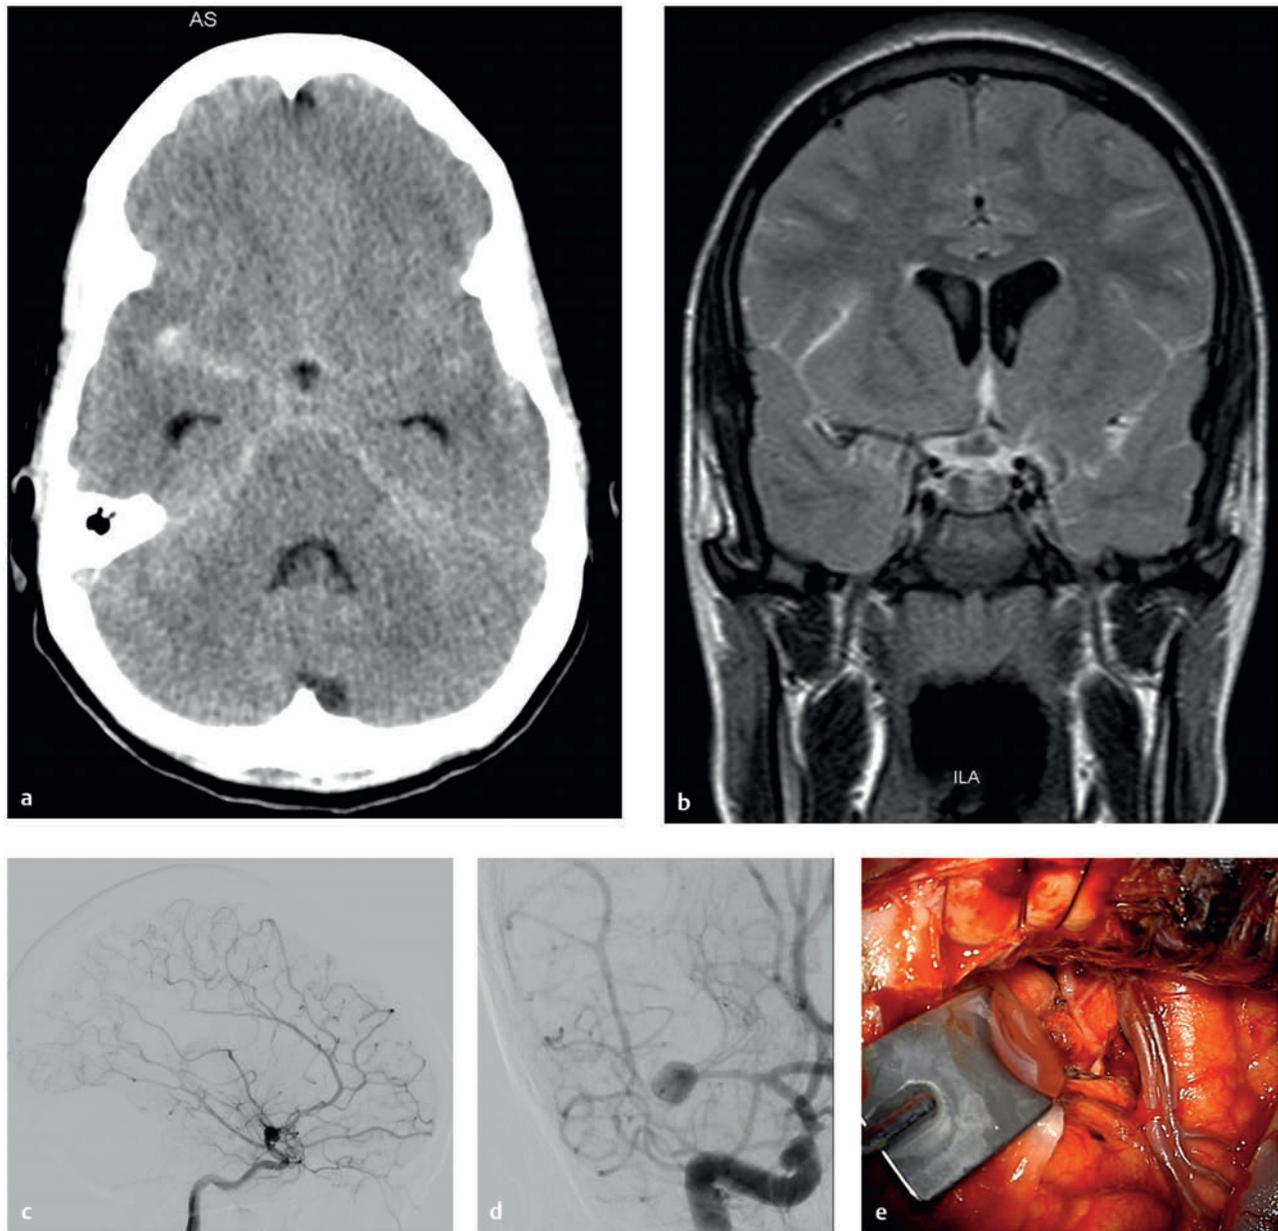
This 17-year-old girl had a history of congenital heart disease and valve replacement surgery. (a) She presented with a subarachnoid hemorrhage as seen on an axial computed tomographic scan, and (b) a mycotic middle cerebral artery (MCA) aneurysm was seen on a magnetic resonance image. The aneurysm enlarged rapidly despite antibiotics, (c,d) as seen on catheter angiography, and she was transferred for surgical care. Note that the superior MCA trunk was occluded at this time. (e) The aneurysm was exposed through a right orbital-pterional craniotomy, (*continued*)
